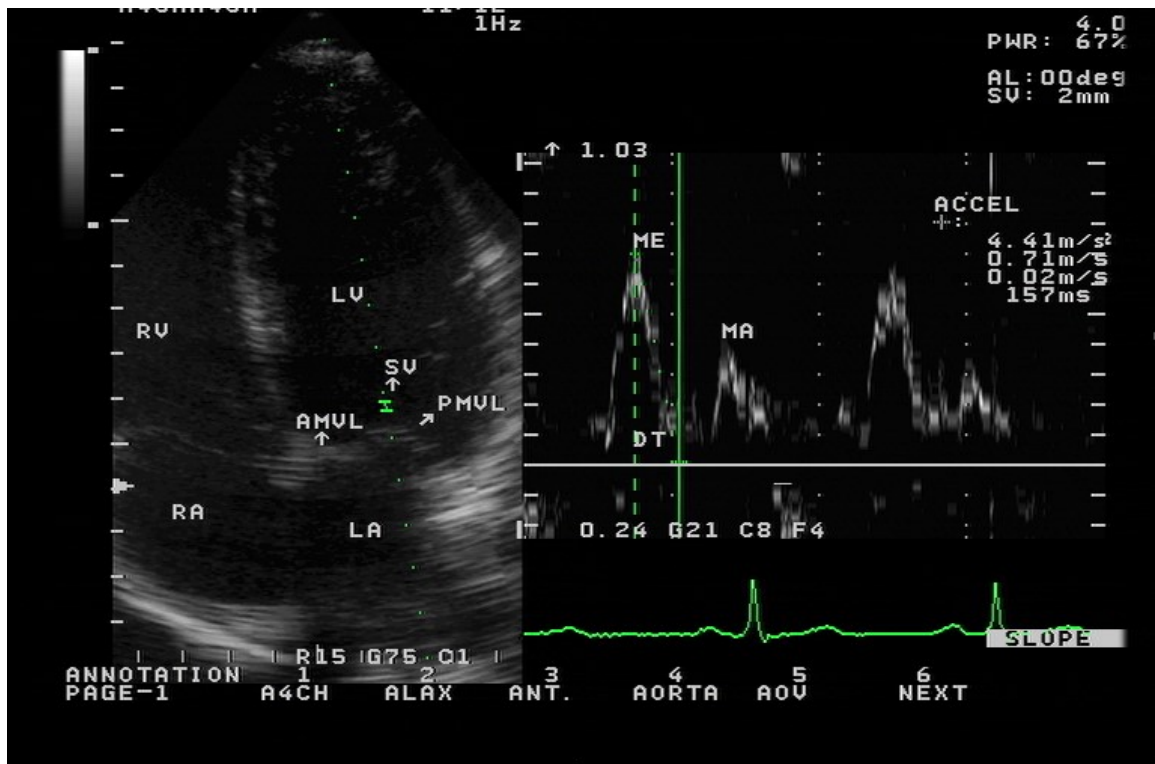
Echocardiogram Showing Measurement of Deceleration Time (DT) of the Mitral 'E' Wave.
